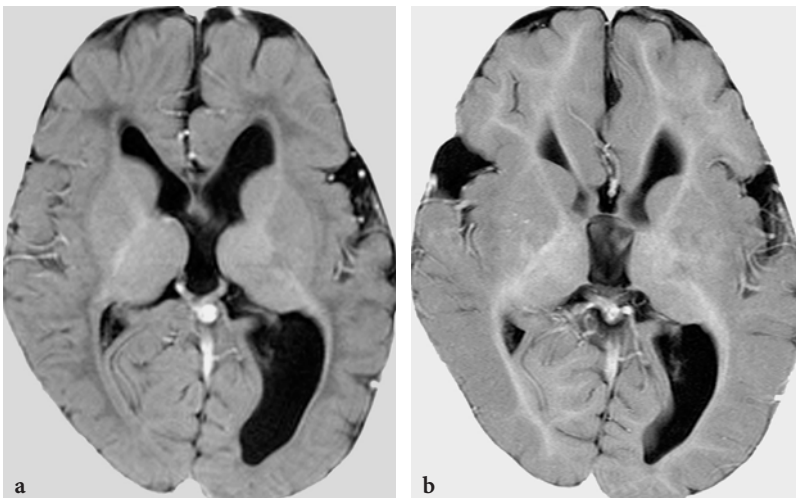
Follow-up MR studies in nonketotic hyperglycinemia. a Axial T1-weighted inversion recovery image in a 10 month-old male patient. Diffuse paucity of the myelin, with severe delay, especially peripherally. b Axial T1-weighted inversion recovery image at the age of 3 years. Some progression of the myelination is well appreciated (compare the signal intensity within the optic radiations, or within the frontal lobes), but overall the myelination remains unaccomplished and severely delayed
